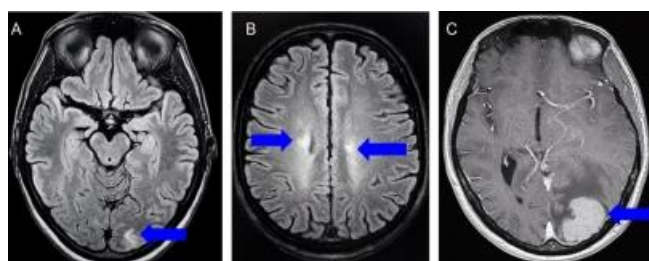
Axial FLAIR brain MRI showing a hyperintense occipital lesion (blue arrow) with surrounding white matter involvement and asymmetry (2022).
